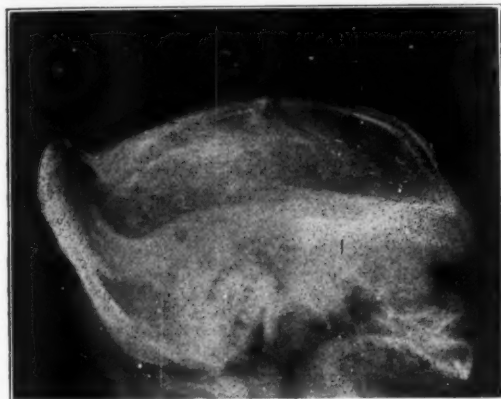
(Case A272457). Lateral roentgenogram of an anencephalic head.
